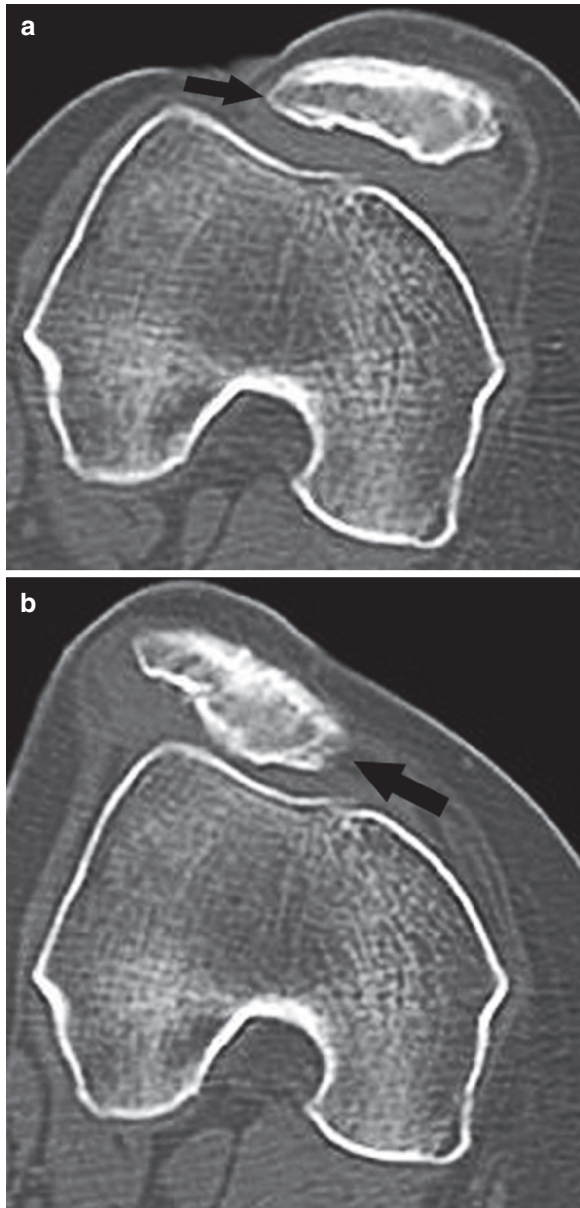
(a) Medial stress CT at 0° extension (finger on the lateral aspect of the patella *black arrow*). (b) Lateral stress CT at 0° extension (finger on the medial aspect of the patella *black arrow*). Note the presence of a shallow trochlea
